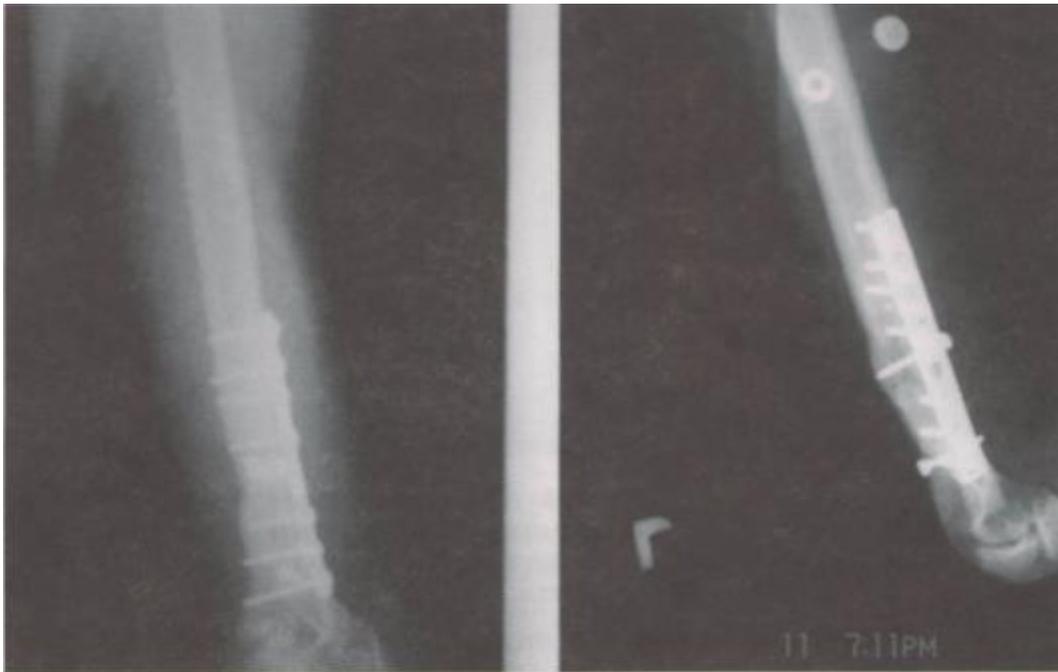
Patient T., 31 years old. X-ray taken after 3 months
